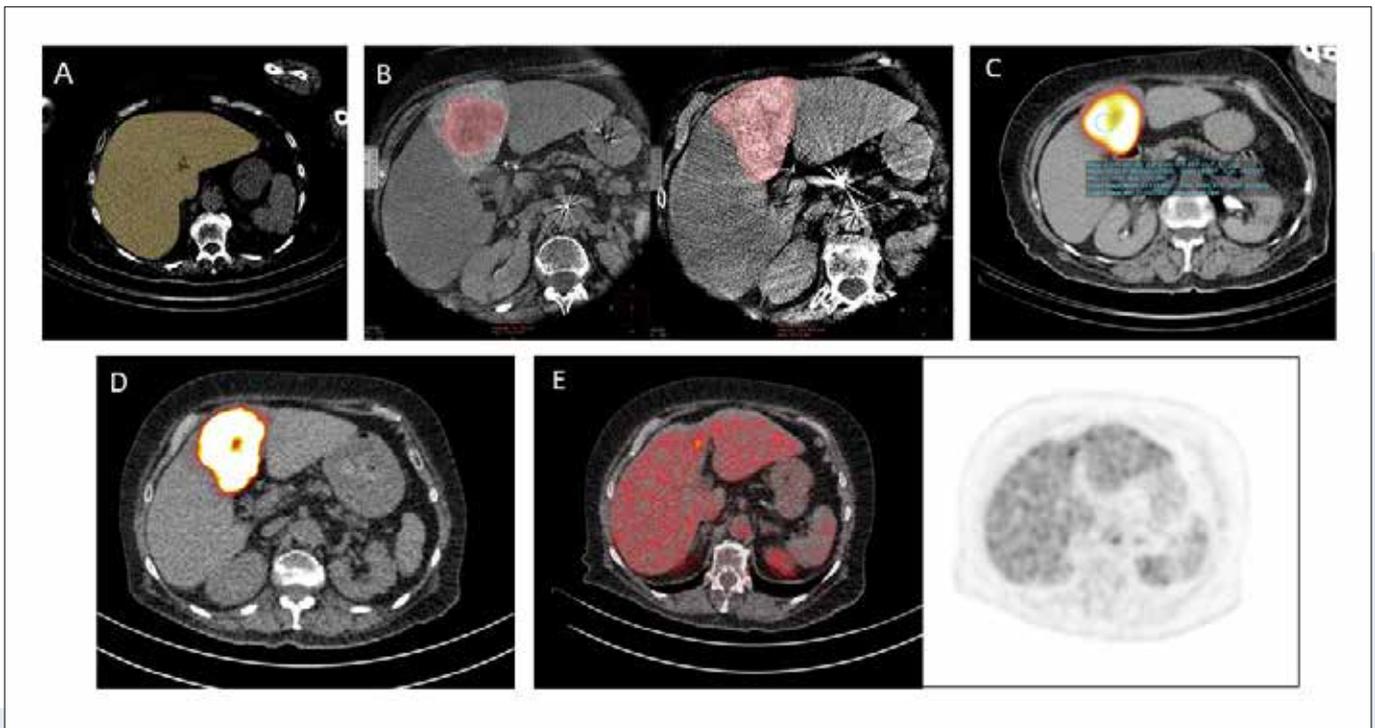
Segmentectomy in a patient with oligometastatic colorectal cancer. Total liver volume determined on CE-CT is 2300ml (A), with one FDG-avid hypervascular tumor lesion located in segment 4. During angiographic work-up a Conebeam-CT is made at the injection position, and treatment volume is segmented (350ml) (B). Tumor-to-normal ratio is estimated at 2.4 on [^{99m}Tc]Tc-MAA SPECT/CT (C). The planned dose on the tumor was 200Gy, resulting in a prescribed activity of 850MBq to the treatment volume. The distribution of ⁹⁰Y-microspheres (D) nicely matches the [^{99m}Tc]Tc-MAA accumulation. Follow-up FDG-PET one year after radiation segmentectomy shows a marked response and no new lesions (E).
